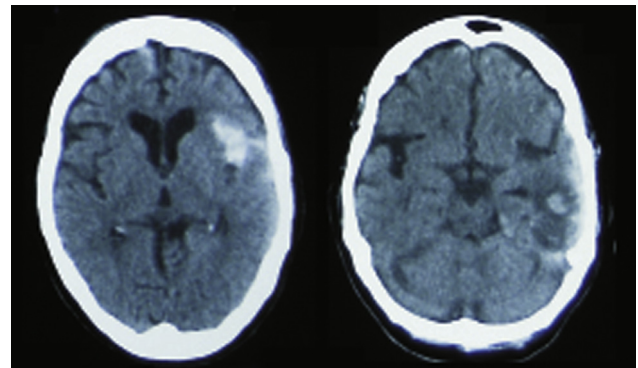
Brain plain CT scan of a middle aged male with road traffic accident showing left temporal contusion and SAH.
